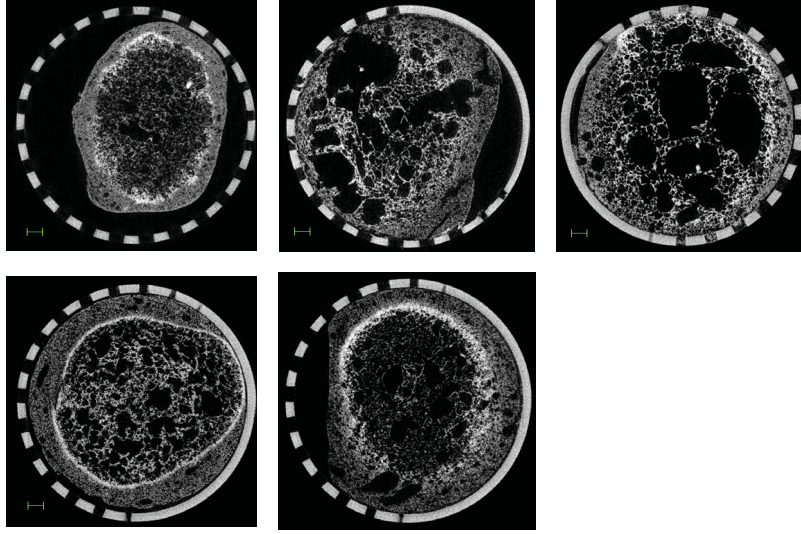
X-ray μ -CT images of DF with PWC 17% (N1 (top left), N5 (top middle), N7 (right), N9 (bottom left) and N13 (bottom middle). Scale indicated in green equals 1 mm.
